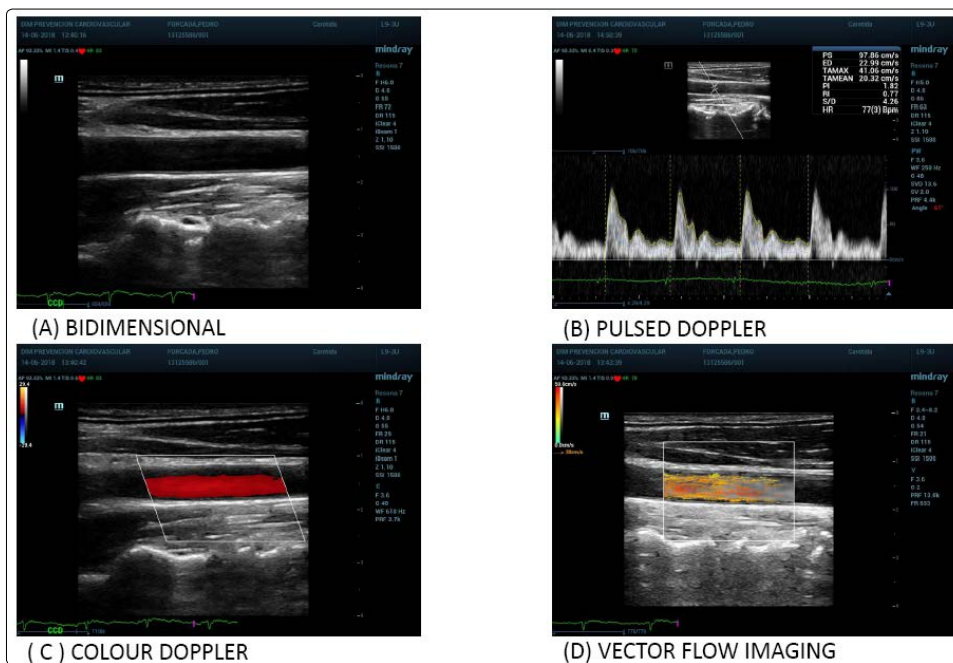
Different ultrasound approaches to study arteries structure and function
